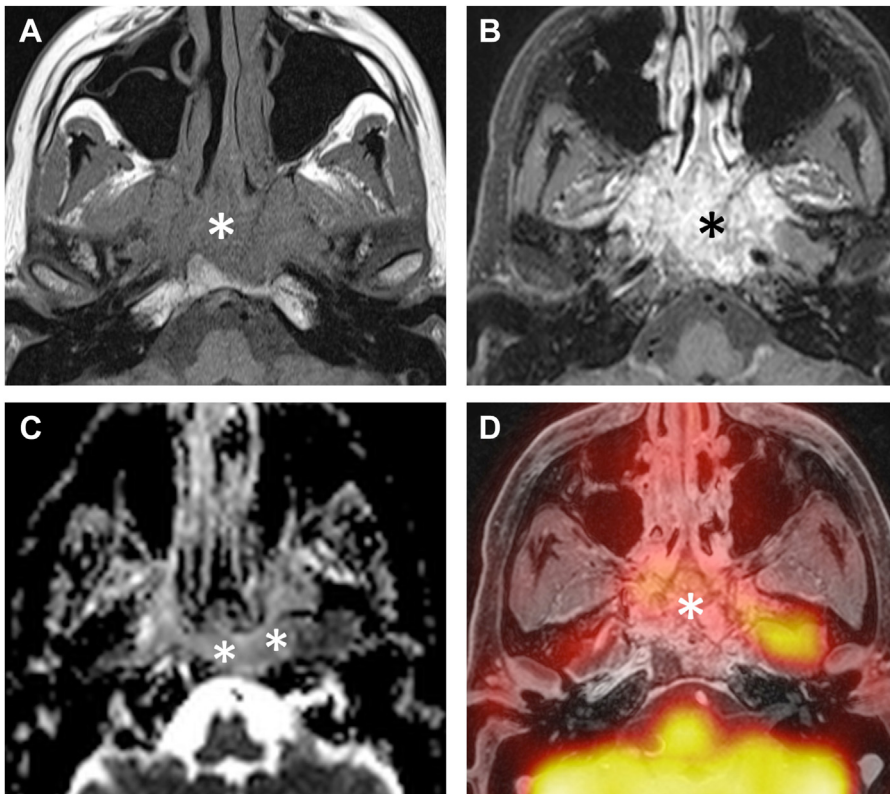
PET/MR imaging obtained 6 months after proton therapy and chemotherapy for undifferentiated sinonasal carcinoma. Recurrence in the nasopharynx was suspected clinically. (A) Axial T1W image shows a large hypointense nasopharyngeal mass (*asterisk*). (B) Corresponding fat-saturated gadolinium-enhanced T1W shows that the nasopharyngeal mass (*asterisk*) invades the clivus and central skull base, suggesting recurrence versus radiation-induced inflammation. (C) ADC map reveals restricted diffusivity ($ADC_{\text{mean}}, 0.98 \times 10^{-3} \text{ mm}^2/\text{s}$) suggesting recurrence (*asterisks*). (D) Corresponding fused PET and gadolinium-enhanced fat-saturated T1 reveal absent FDG uptake (*asterisk*) suggesting inflammation. Surgical biopsy and follow-up greater than 3 years revealed inflammatory tissue. (Images B, C, and D reproduced from Becker et al 2014.¹)
